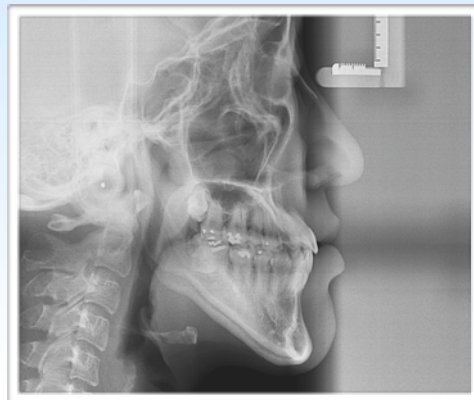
Post-treatment pano and ceph radiographs
